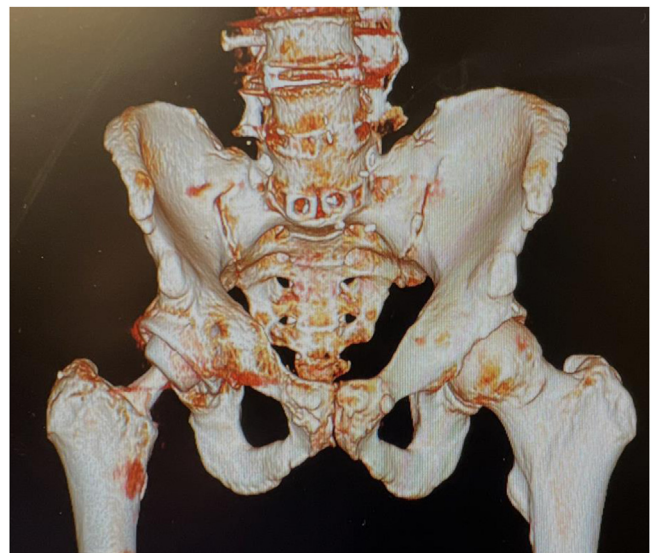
Three-dimensional pelvis computed tomography reconstruction after right total hip arthroplasty with substantial anterior overhang of right acetabular component.
